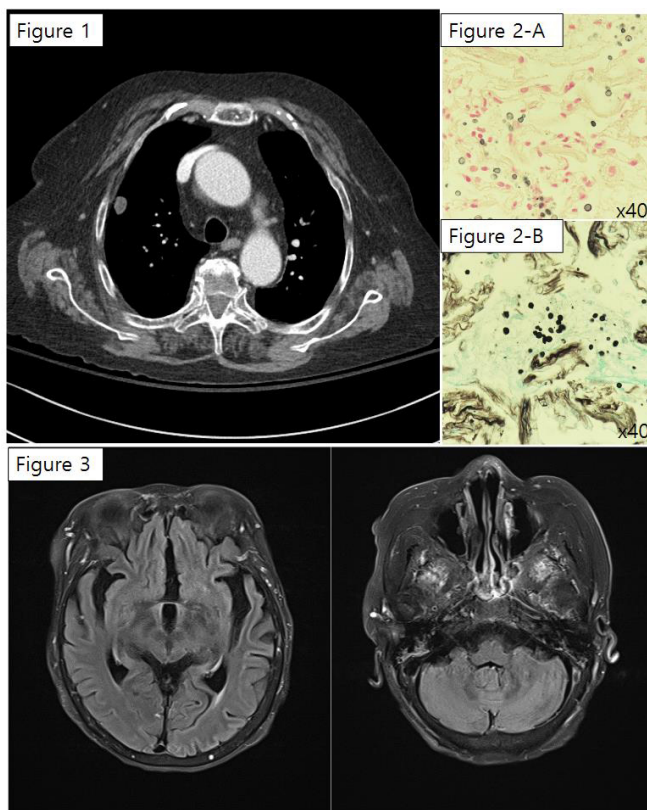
A non-enhancing low-attenuation nodule with an oval shape was detected in the right upper lobe on the Chest CT.
